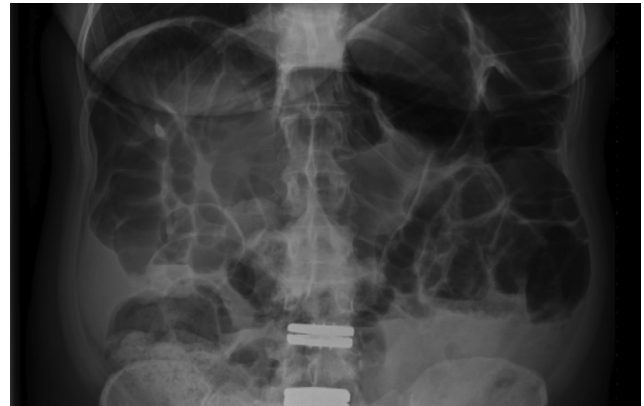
Abdominal radiograph of a patient with aerophagia showing a large volume of intestinal and colonic air; there are some signs of constipation as well but no air-fluid levels. Impedance monitoring showed massive air swallowing.
